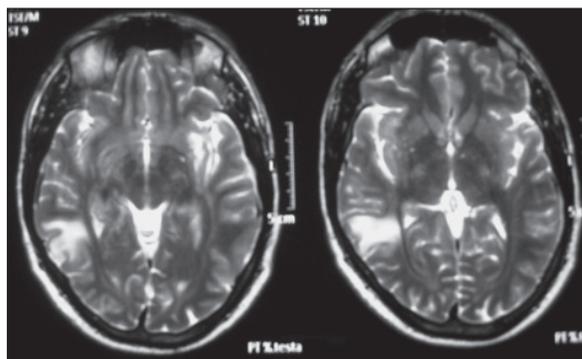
Cranial MRI showing a high T2 signal in the brain subcortical area and white matter of the right temporal lobe, as signs of inflammation and/or ischemia. Smaller lesions were found by MRI in the basal ganglia, thalamus and lamina interna.
